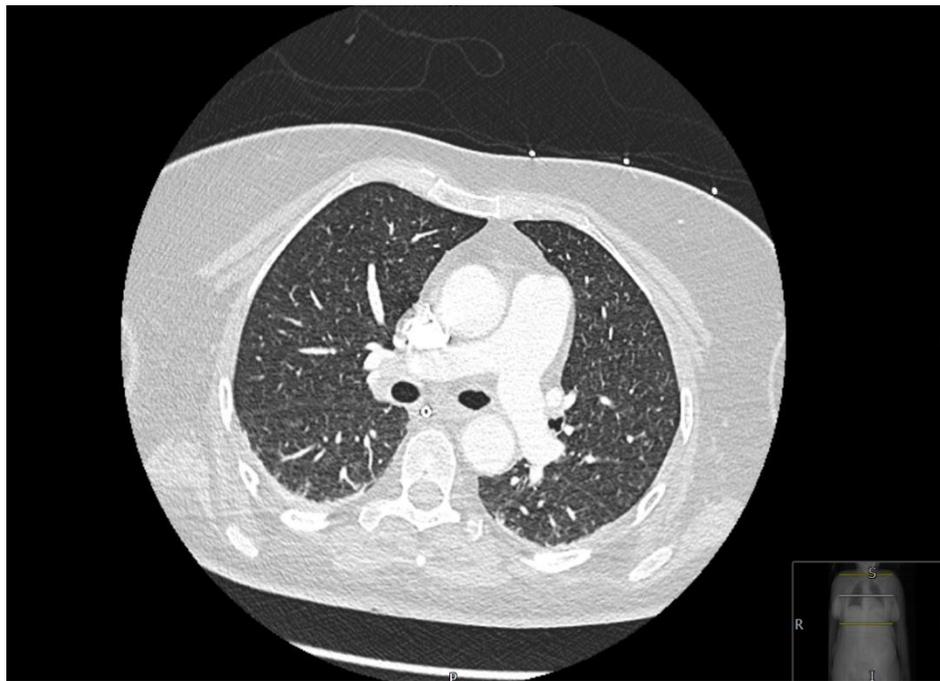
CT CAP during admission to ITU suggesting possible bronchiolitis/TB
